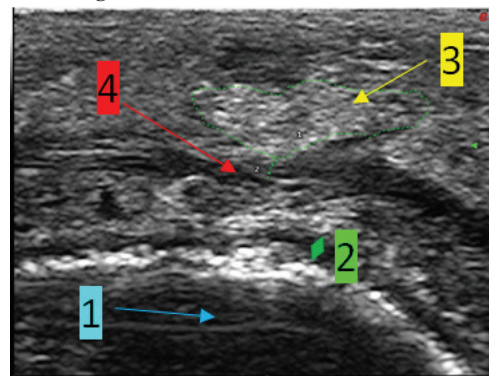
Sonogram, B-mode, the lateral part of the upper lip, horizontal plane (arrow 1 – oral cavity, arrow 2 – submucosa). The hyperechoic formation (arrow 3 – hyperechoic formation) with clear uneven contours is visualized above the orbicularis oris muscle (arrow 4 – m. orbicularis oris). It was located at the site of HA filler injection. Echo signs of fibrotic changes into the soft tissues of the upper lip
